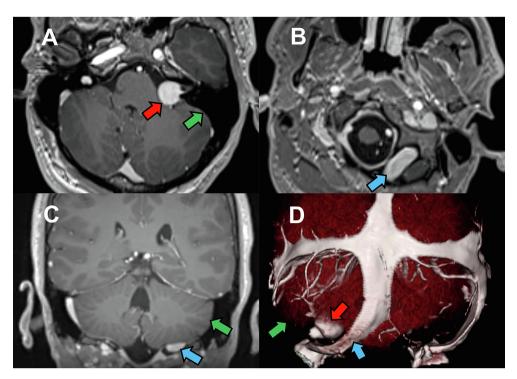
A) Axial T1-weighted gadolinium-enhanced MRI showing a Koos grade III, 2.9 cc left vestibular schwannoma [red arrows] in a 21-year-old male. B) Axial and C) coronal T1-weighted gadolinium-enhanced views showing a left side oblique occipital sinus (OOS) [blue arrows]. D) 3D reconstruction MRI showing the left side OOS draining into a hypoplastic/aplastic left sigmoid [green arrows] - jugular bulb sinus.
